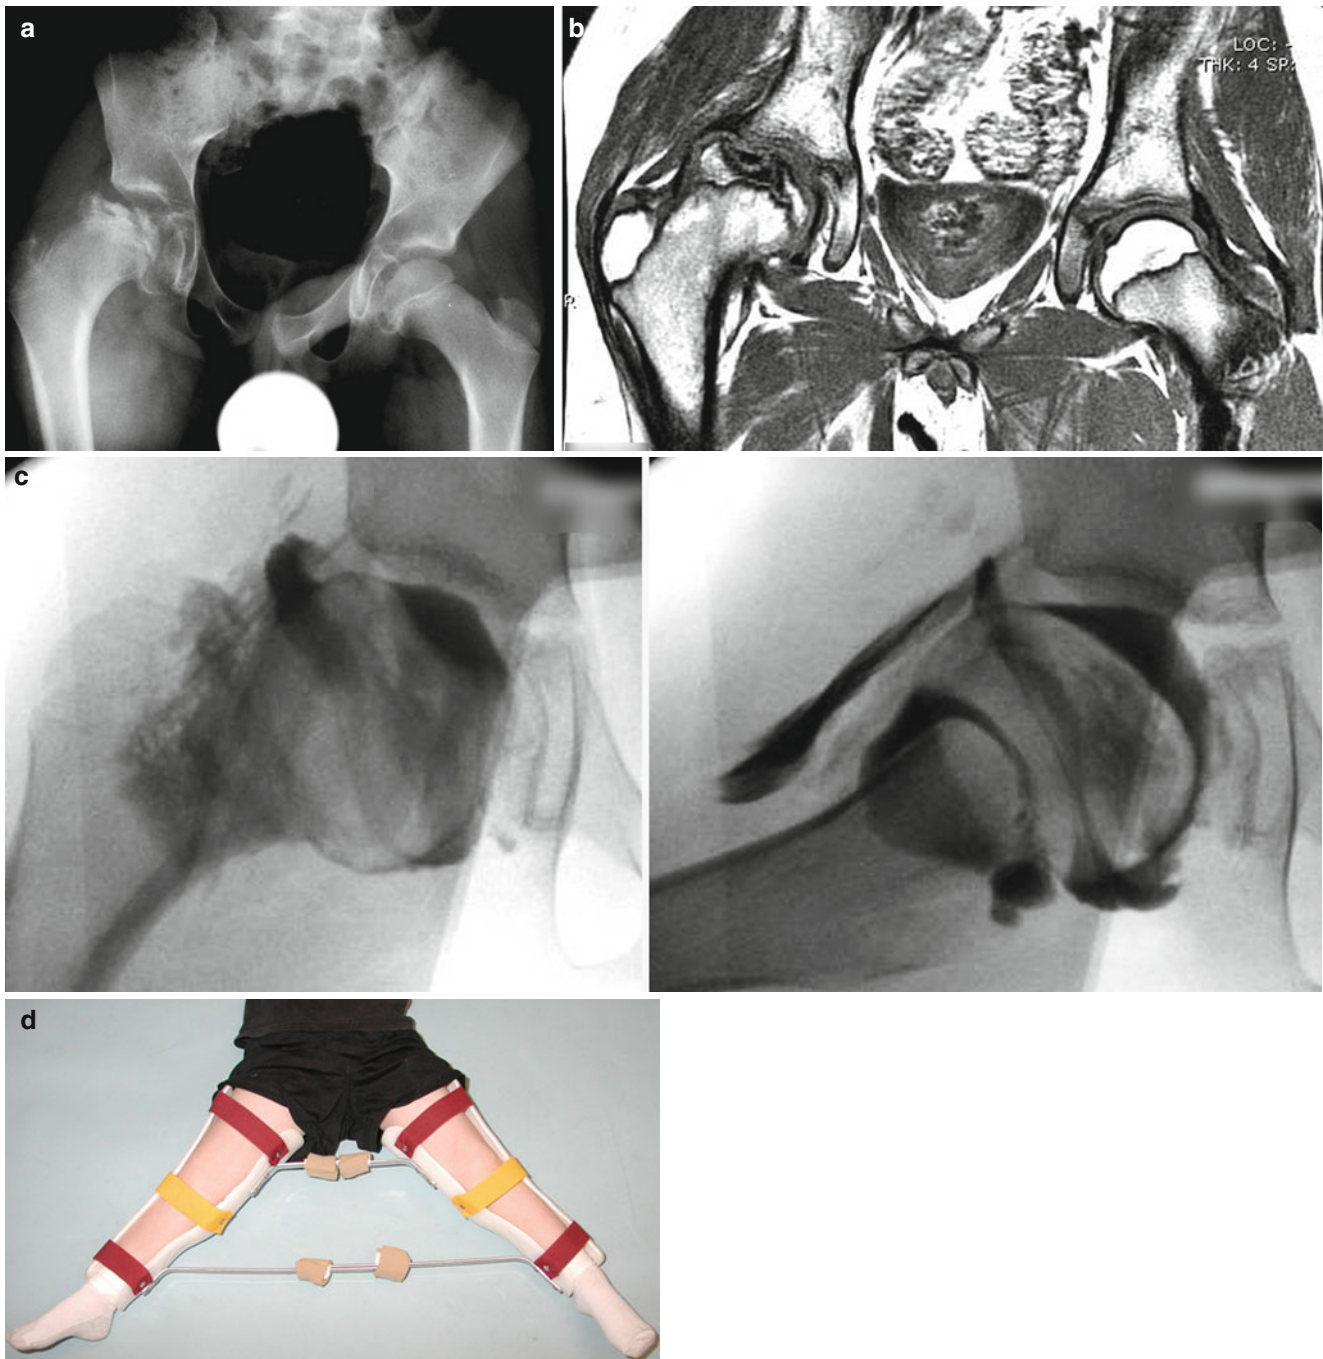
A 10-year-old male complaining of right hip pain for 1 year and 2 months. This patient was treated in another institution with physiotherapy and a period of immobilization. When the patient presented for a second opinion, he had a very stiff hip with adduction and flexion contracture. (a) AP radiograph showing fixed adducted position of the right leg, fragmented and deformed epiphysis with lateral extrusion. (b) MR T1 image showing the depression in the lateral aspect of the epiphysis by the lateral edge of the acetabulum. (c) Hip arthrogram
